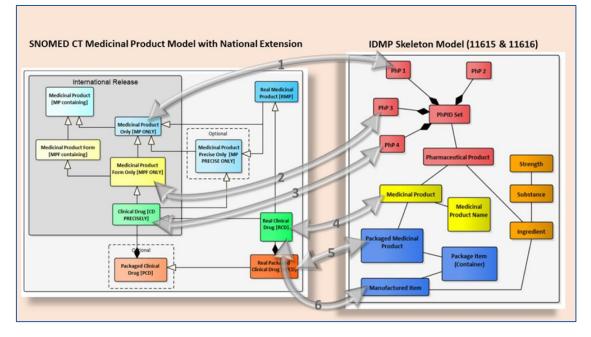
SNOMED CT Product Model relation to IDMP Skeleton Model
